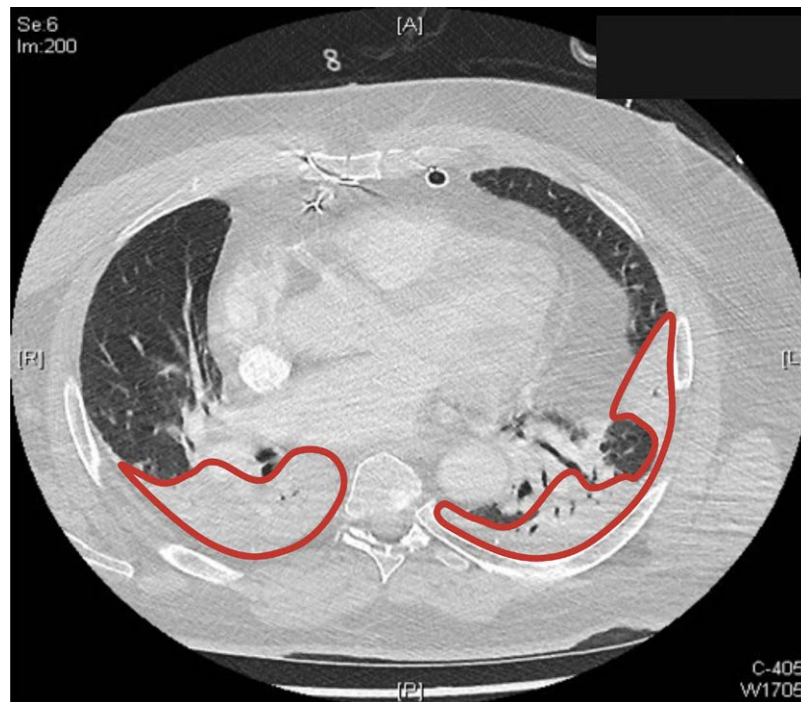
Lung computed tomography: bilateral opacities of the dependent retrocardiac lung regions (*red lines*) revealing the typical aspect of severe perioperative pulmonary atelectasis in an obese patient requiring reintubation for postoperative respiratory failure 2 days after coronary artery bypass graft surgery.
